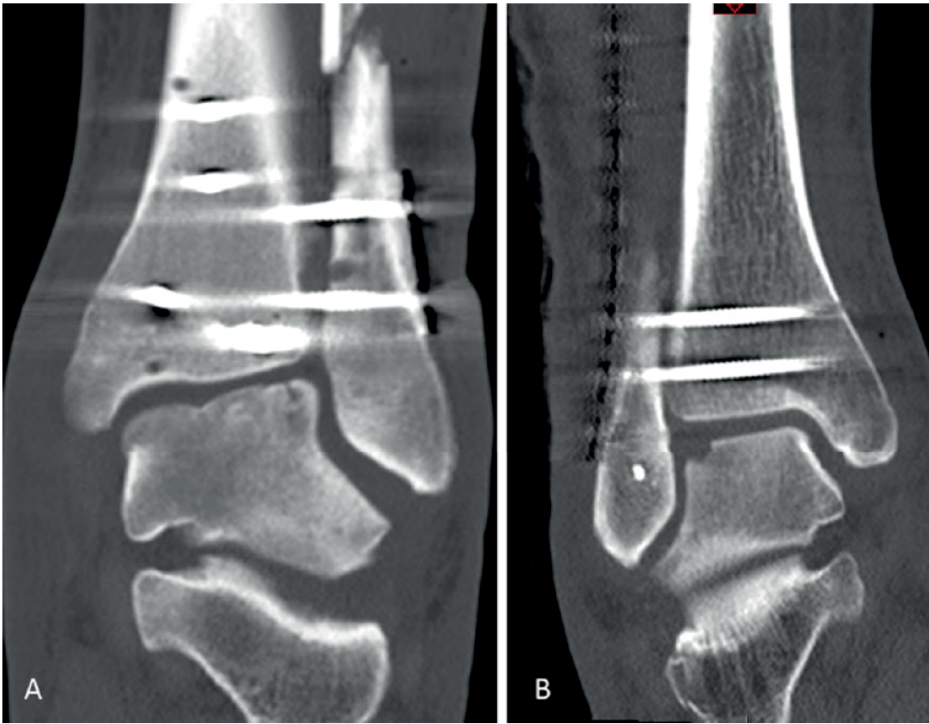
Examples of a Berndt and Harty (A) type III and (B) type IV osteochondral lesion seen on postoperative CT.
